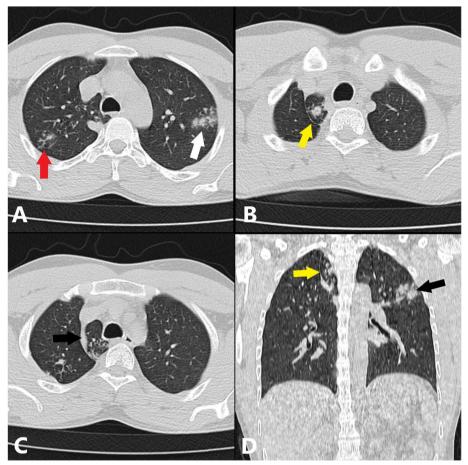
a–d Axial HRCT thorax demonstrates. a Nodular opacities in bilateral upper lobes (white arrow) with tree-in-bud nodularity in right upper lobe. b Azygos fissure and lobe (yellow arrow) showing nodularity within. c Azygos vein (black arrow) seen as a thick curvilinear density caudal to the azygos fissure. Nodularity within azygos lobe and right upper lobe was also seen. d Coronal HRCT thorax demonstrates lung nodules within the azygos lobe (yellow arrow) and left upper lobe (black arrow)
